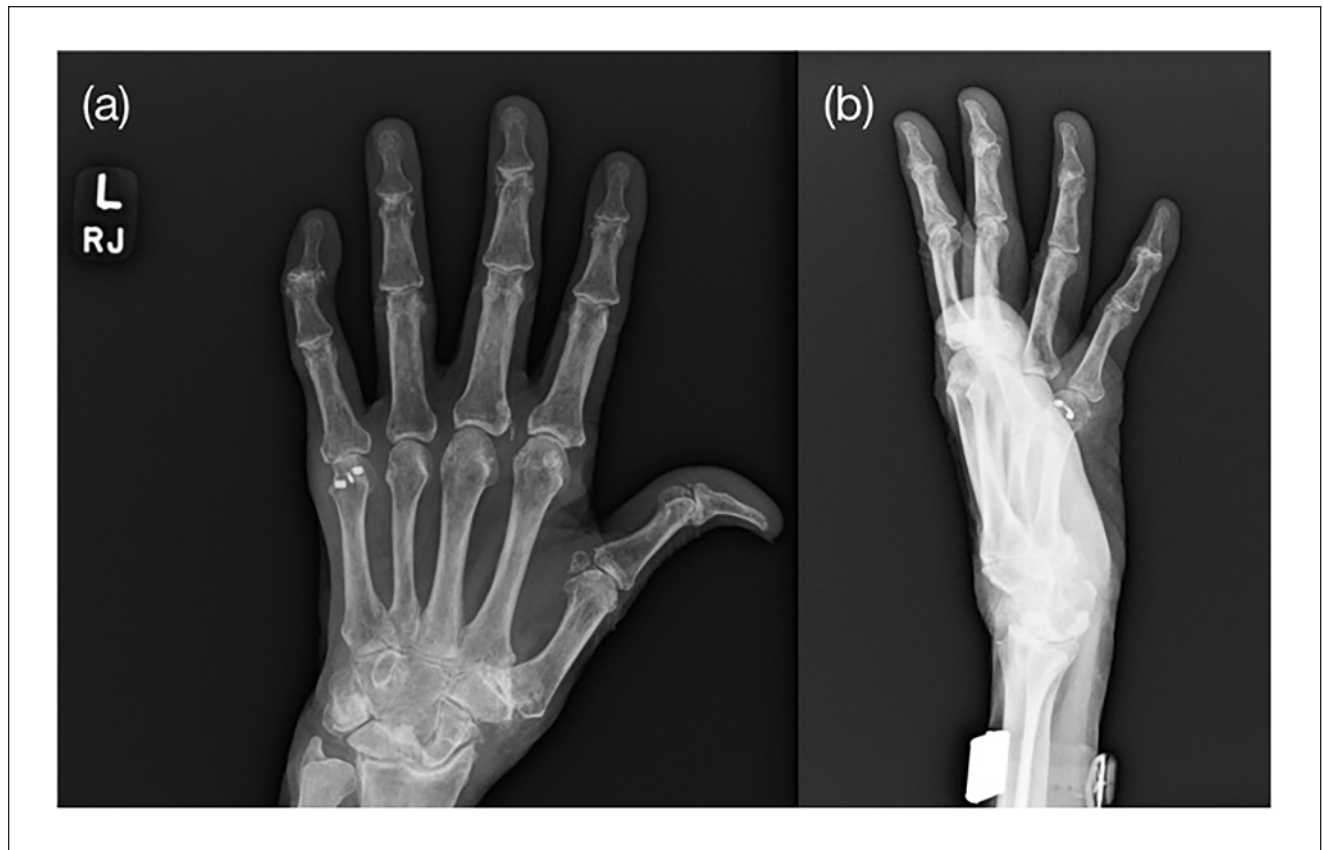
Six-week postoperative (a) posteroanterior and (b) lateral radiograph demonstrating a reduced metacarpophalangeal joint of the left little finger. Nano and corkscrew anchors placed intraoperatively are in the correct position.
